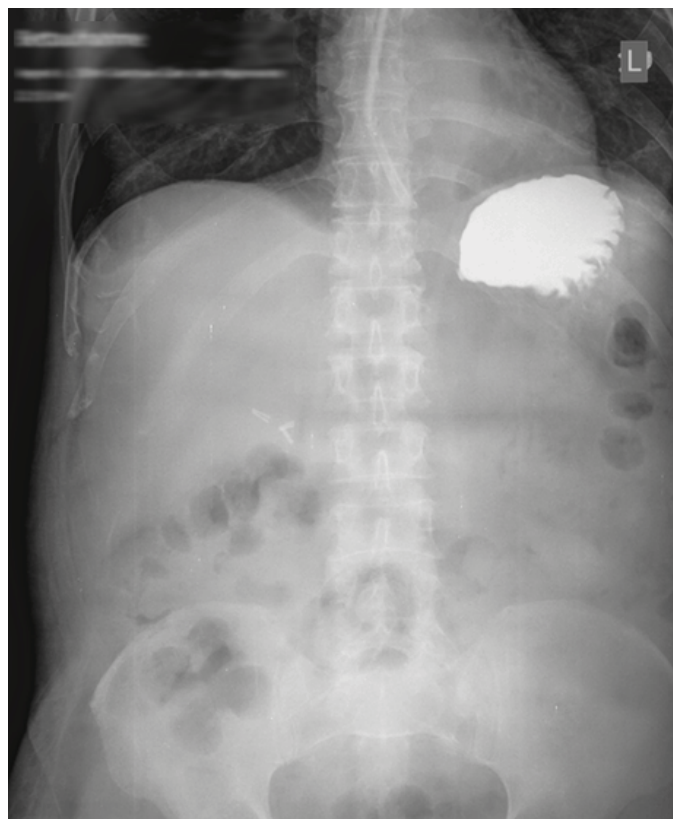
Abdomen X-ray shortly after the administration of 100 ml gastrografin.
